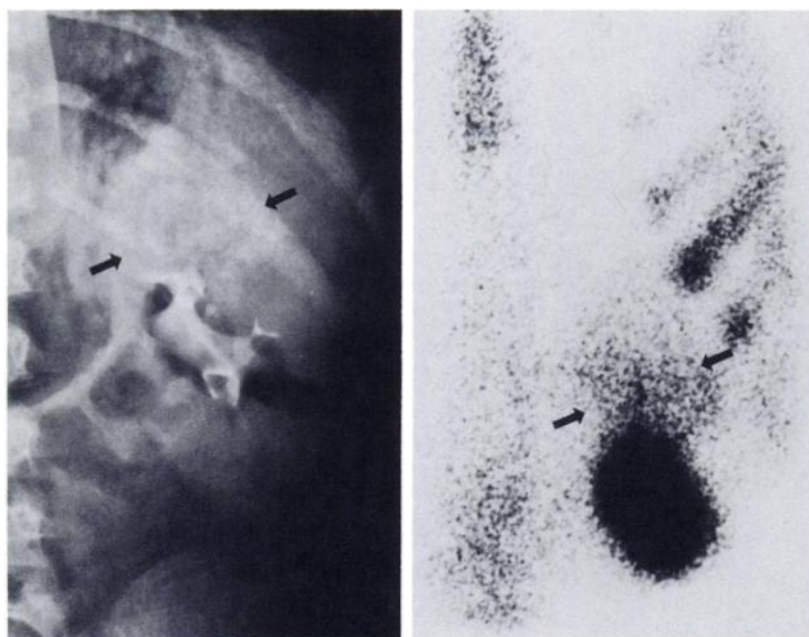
Tracer uptake in tumor mass (arrows) corresponds to site of calcification seen on plain film (arrows).
